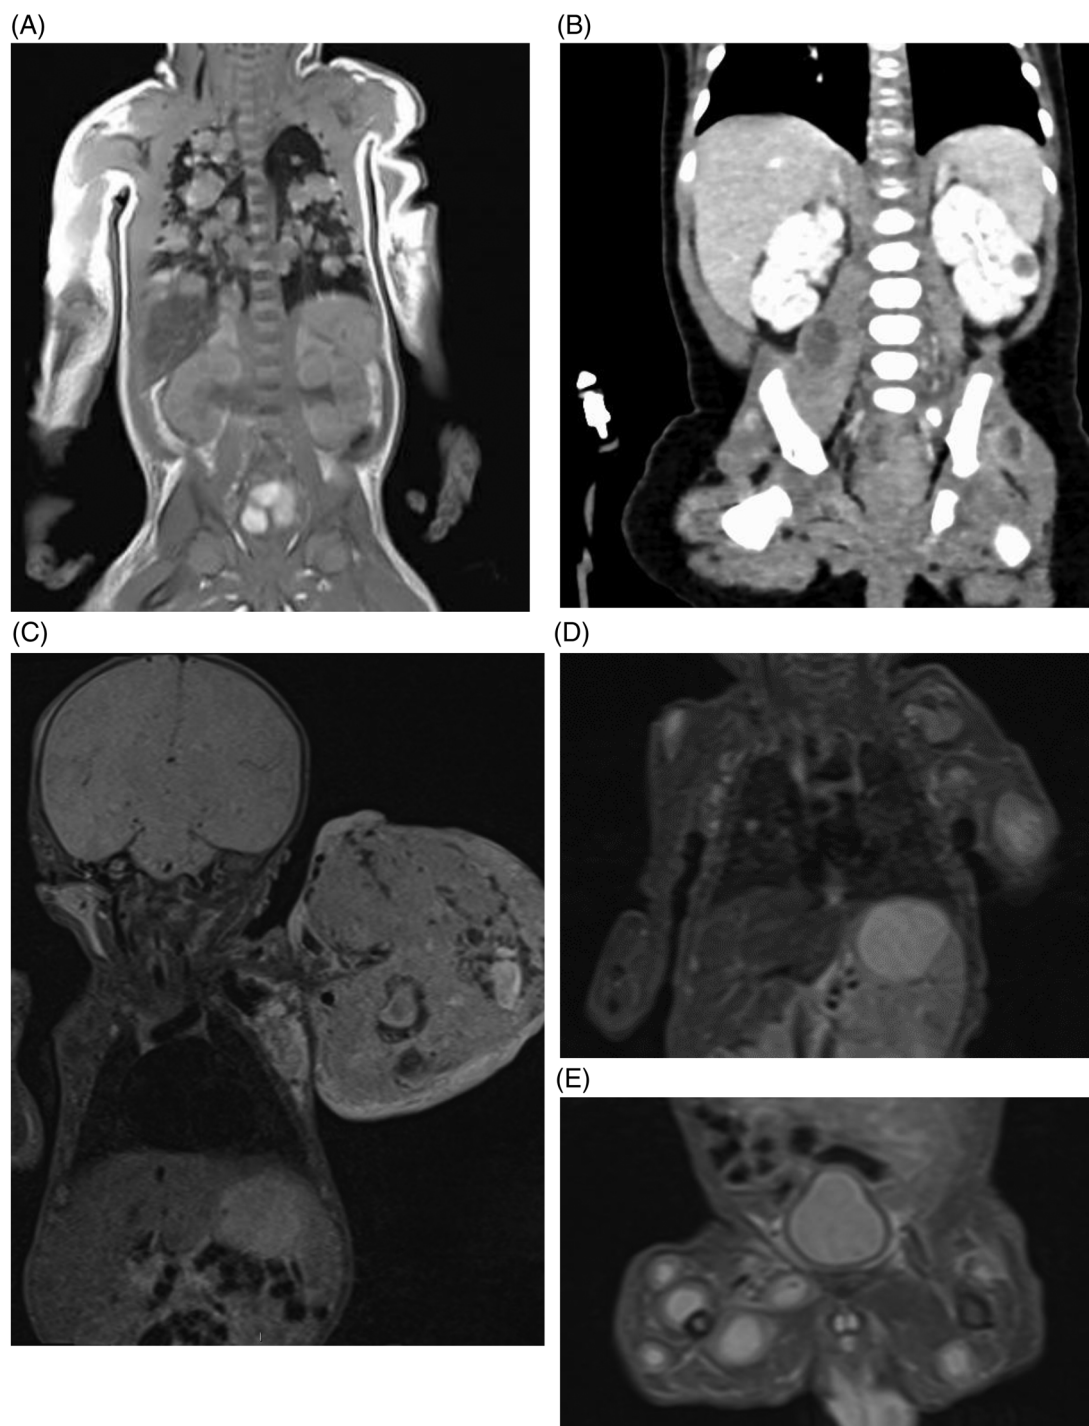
MRI images demonstrating extent of disease in each case. (A) Extensive pulmonary disease in case 1, abdominal disease not appreciable by MRI. (B) Renal, retroperitoneal nodal, and intramuscular disease deposits in case 2, following surgical resection of ovarian disease. (C) Large unifocal myofibroma in case 3. (D and E) Extensive subcutaneous disease with pulmonary and liver nodules in case 4
